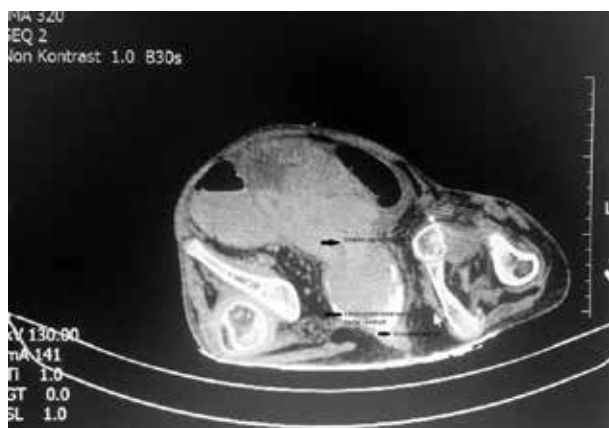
Abdominal CT image of the patient
